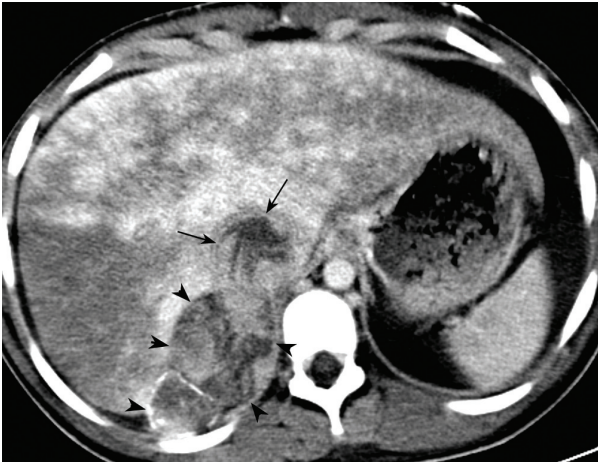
Contrast-enhanced CT scan of upper abdomen shows an enhancing mass in the right adrenal gland (arrowheads), extending into the intrahepatic inferior vena cava (IVC) see arrows. Geographic hepatic parenchymal enhancement together with IVC occlusion by enhancing tumour thrombus indicates hepatic venous outflow obstruction (Budd-Chiari syndrome)
